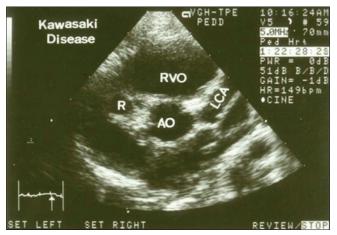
Parasternal short axis view is showing a fusiform aneurysm of left coronary artery and a saccular aneurysm of right coronary artery. RVO: right ventricular outflow tract, R: aneurysm of right coronary artery, AO: ascending aorta, LCA: left coronary artery aneurysm
